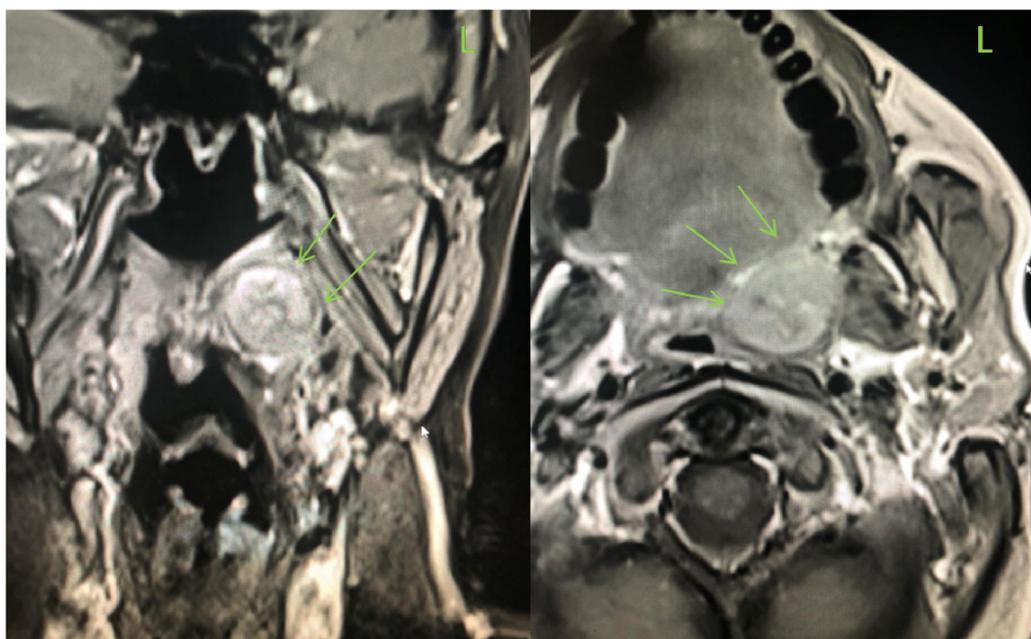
Neck MRI findings – encapsulated tumor in the region of the soft palate on the left (arrows)
